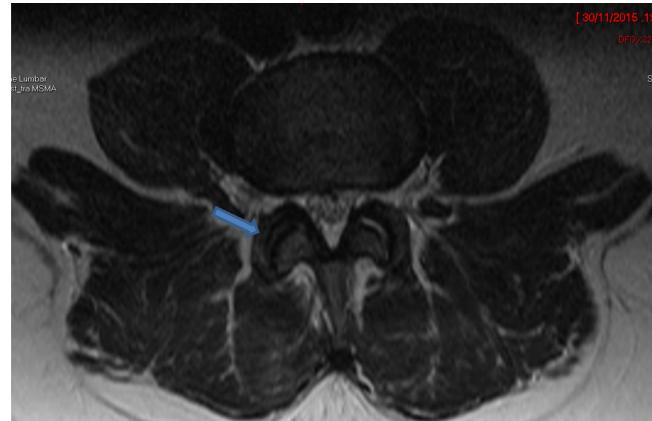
Follow up MRI scan after six weeks showing complete resolution of septic arthritis in the facet joint.
